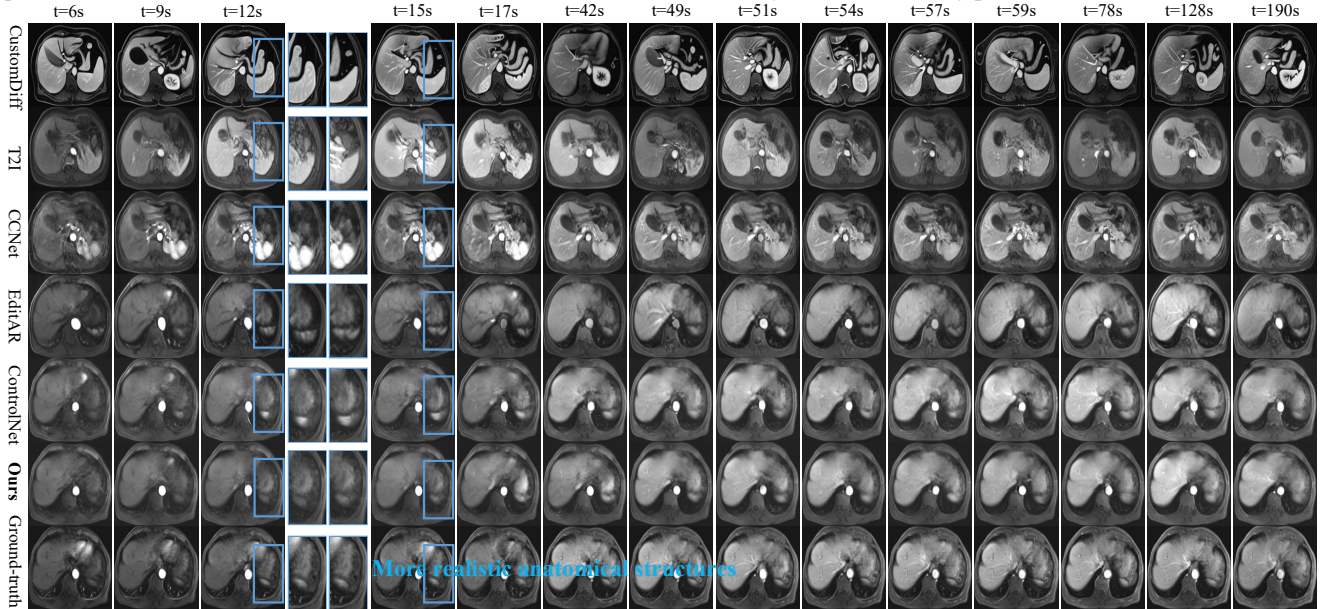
Visualization results in Abdominal DCE-MRI: The visualization results of our methods on different time points exhibit better spatial reality (zoom-in regions in blue boxes).
